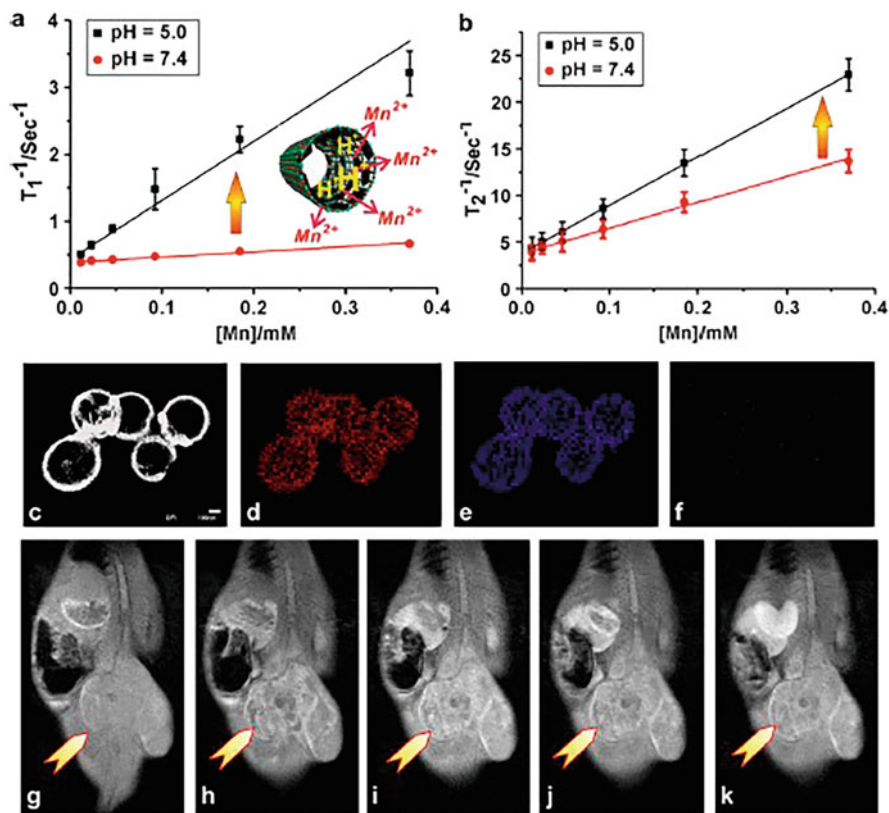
T₁ (a) and T₂ (b) relaxivity of aqueous suspension of HMCNs after 4 h soaking in buffer solutions of different pH values (7.4 and 5.0) at 37 °C; STEM image (c, scale bar ¼ 100 nm) and corresponding element mappings of O (d), Si (e), and Mn (f) of HMCNs after the soaking in pH ¼ 5.0 buffer solution for 4 h; in vivo T₁-weighted MRI of tumor before (g) and after intravenous administration of HMCNs (h 5 min, i 15 min, j 30 min, k 60 min; arrows indicate the tumor tissue). Reproduced with permission from Chen et al. (2012), copyright 2012, Elsevier Ltd
